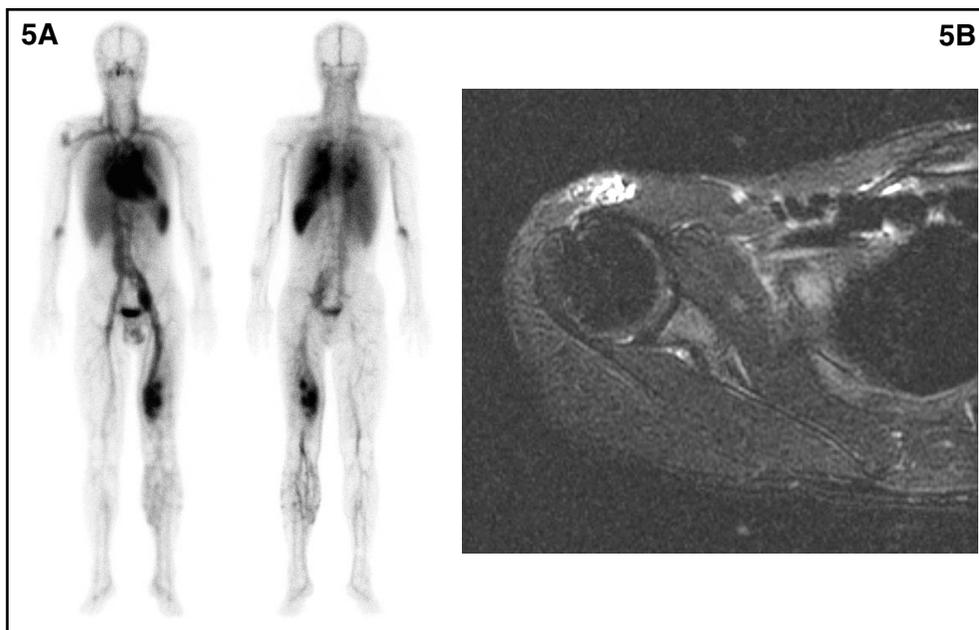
(A) WBBPS of a 27-year old male patient with a suspected CVM in the left thigh shows additional abnormal blood pooling in the right shoulder and arm along with left thigh and pelvic area blood pooling lesions. (B) MR T2-weighted transverse image performed after WBBPS confirmed an additional low flow-type VM in the right shoulder.
